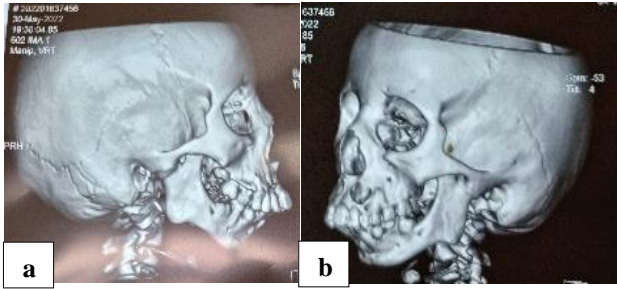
(a and b): 3D CT scan shows complete true bony ankylosis on bilateral side (Sawhney type 4) as TMJ was completely replaced by bone.
